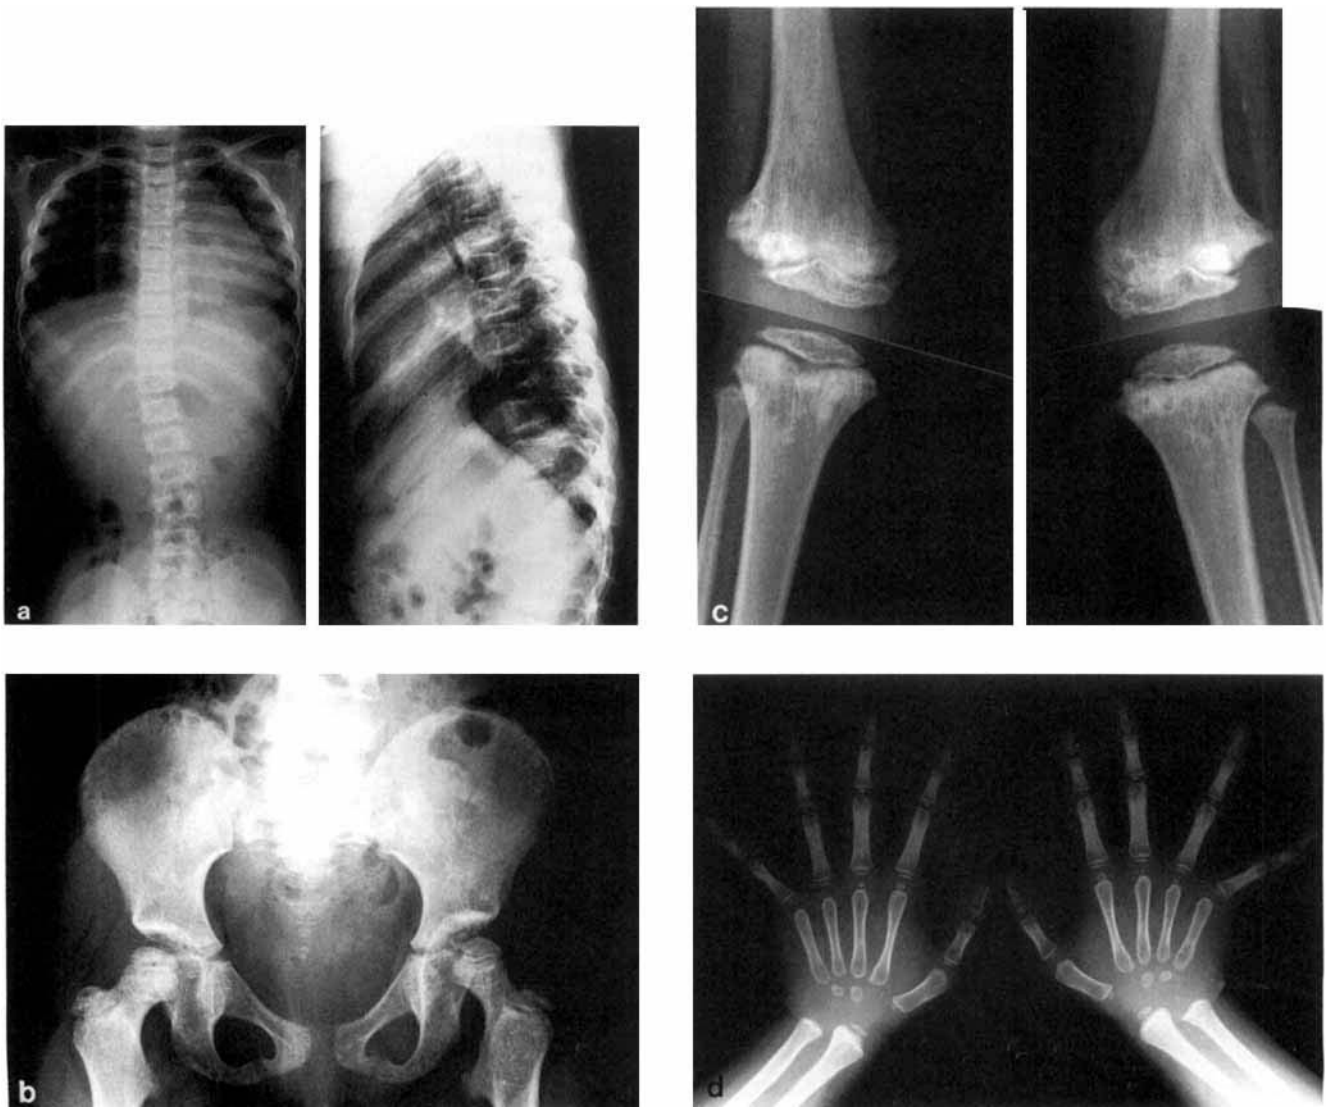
Age 6 years. a: Anteroposterior and lateral radiograph of spine. Note indentations on the superior and inferior aspects of the vertebral endplates. b: Pelvis and femora. c: Anteroposterior radiograph of knees. Note markedly delayed epiphyseal ossification, evident metaphyseal dysplasia, and dense metaphyseal striations. d: Radiograph of hands.
